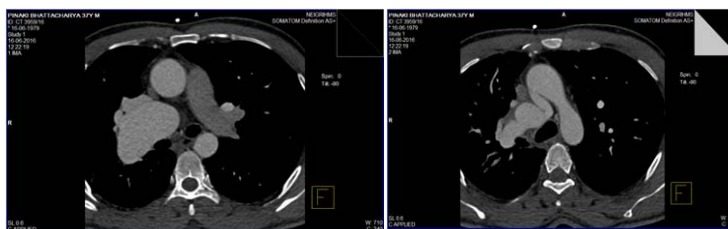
Transaxial CT angiogram with intravenous contrast in a soft tissue window (A) shows an absent left pulmonary artery (B) tortuous, dilated arterial branches supplying right lung
